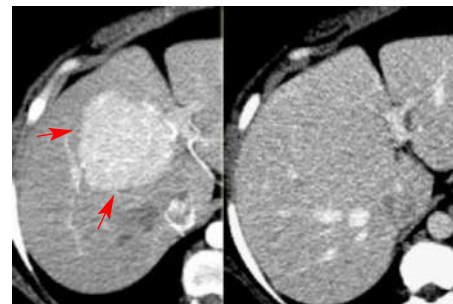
Focal nodular hyperplasia, Magnetic Resonance Imaging (arrows).
